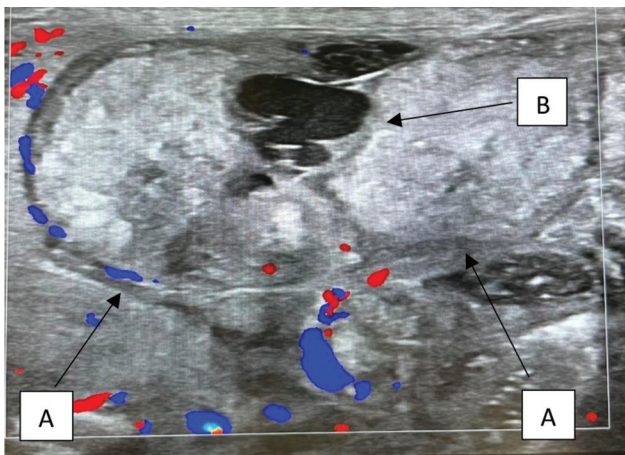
Abdominal ultrasound showing two distended intestinal loops (A) with increased blood flow and fluid (B) between them.
